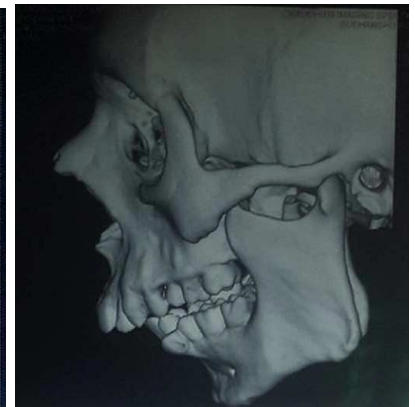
Pre Operative CT Scan 3D (Left)
